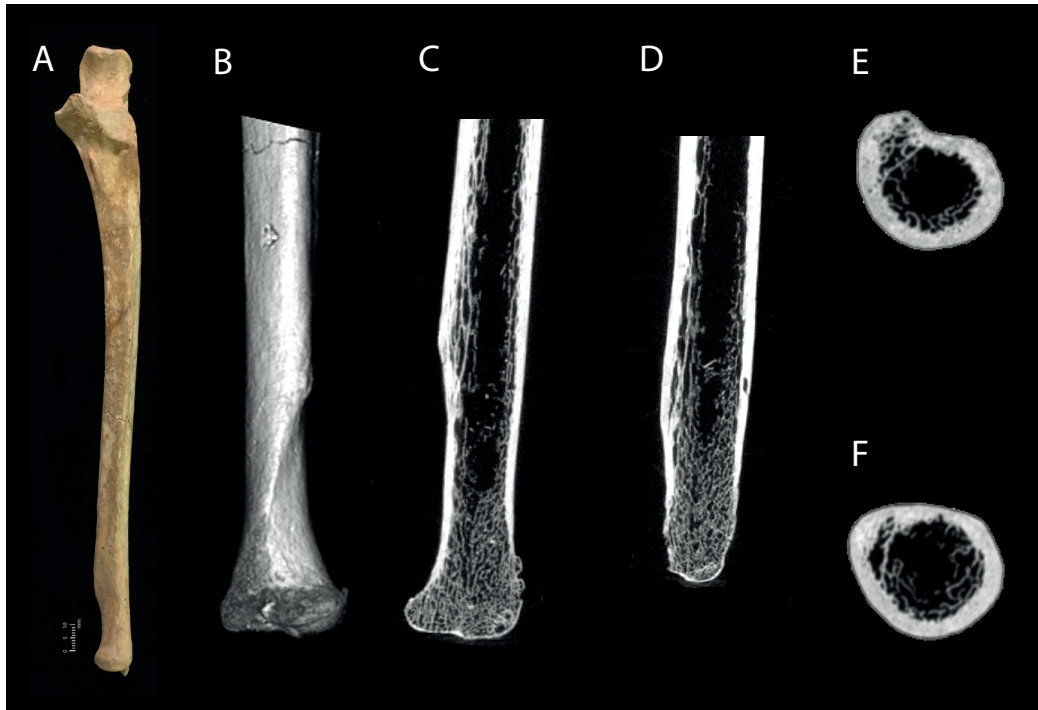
A selection of photographic and radiological images pertaining to an adult left ulna (FB0009) from Context (951) of the Circle sample, detailing a healed fracture of the distal diaphysis, including: a) anterior view; b) 3D render, lateral view; c–d) coronal cross-sections from CT data, detailing cortical dysplasia and deeper internal margin of medullary wall; e–f) transverse cross-sections moving superiorly to inferiorly through the diaphysis, internal margin of medullary wall. Scale bar: 1 cm (photograph only). (Photo Ronika K. Power; radiological images captured by L. Buck, Cambridge Biotomography Centre; processed by J. Magnussen & M. Pardey, Macquarie Medical Imaging).
